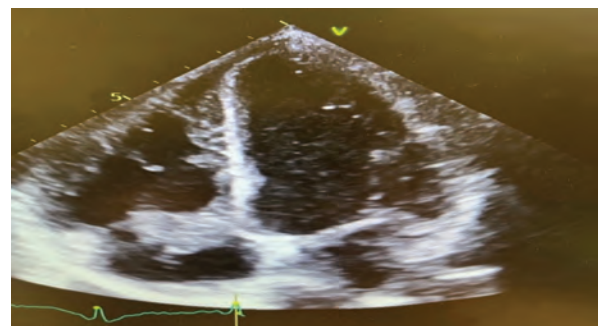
Echo; Apical 4 chamber view
